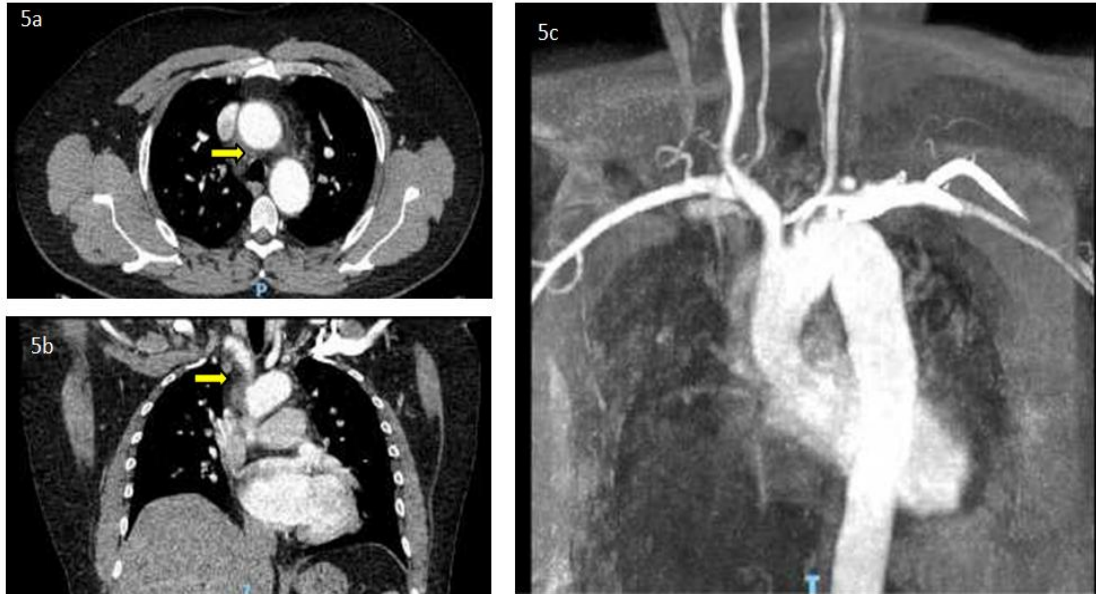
CT aortogram (axial and coronal view) highlighting periaortic inflammation around the thoracic aorta, brachiocephalic vessels and occlusion of left subclavian artery (solid arrows). Fig. 5c. MR angiogram showing significant periaortic inflammation
